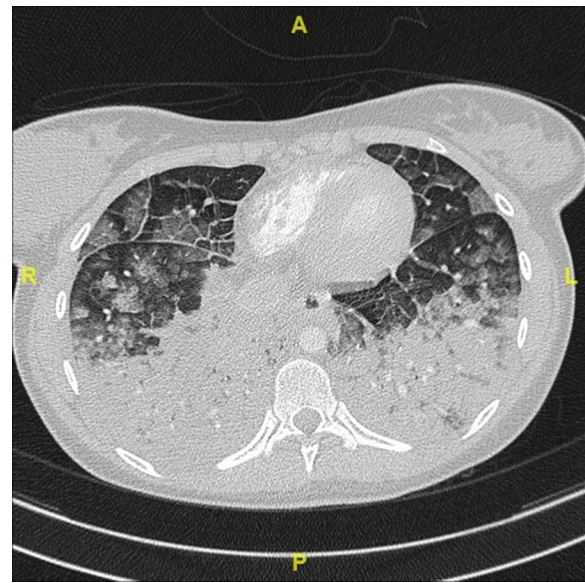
Chest computed tomography (CT) showing bilateral multiple confluent consolidations located mainly in the posterior aspects of the lower lobes associated with regions of ground-glass opacities in the upper lobes and diffuse thickening of interalveolar septa
